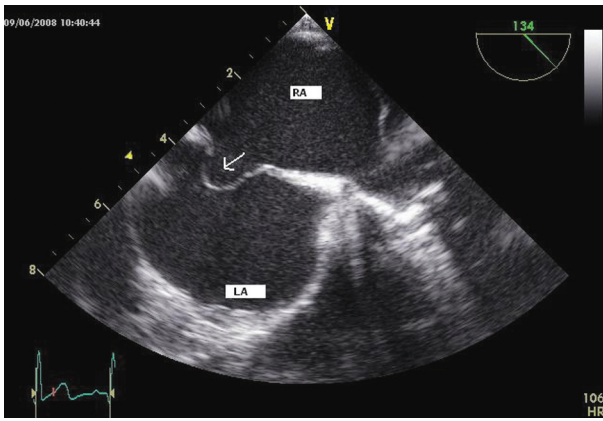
Transesophageal echocardiographic view of a secundum atrial septal defect. Arrow shows the secundum atrial septal defect
